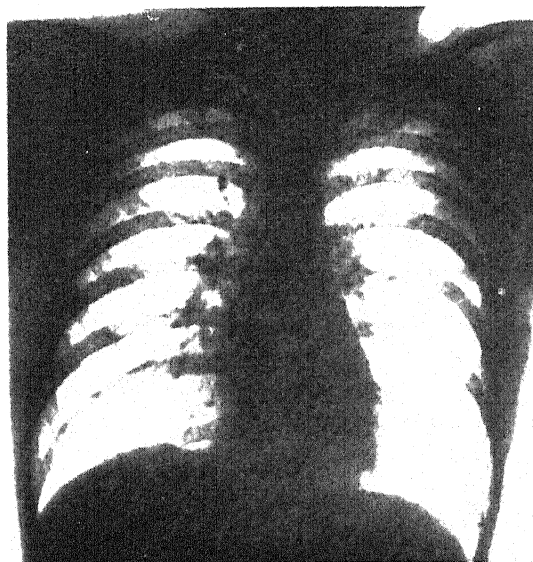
X-ray of thorax of the same person in forced inspiration. Observe the increase in the transverse and vertical diameters of the thorax, the descent of the diaphragm, and the increase in the costophrenic angle.
